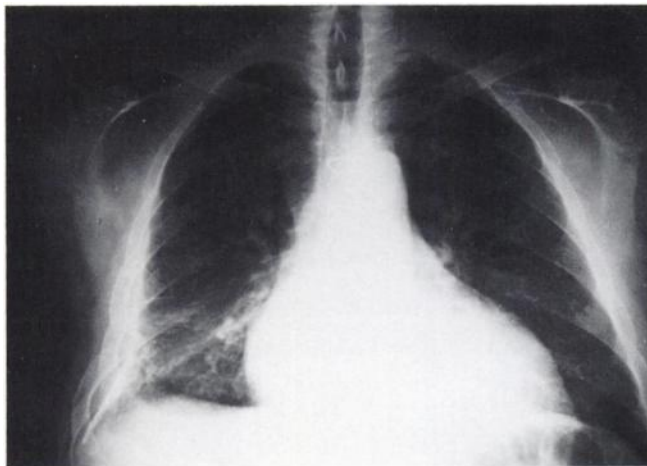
Chest x-ray demonstrates cardiomegaly with no evidence of active disease or CHF. Parenchymal and pleural changes at the right base represent chronic scarring.
